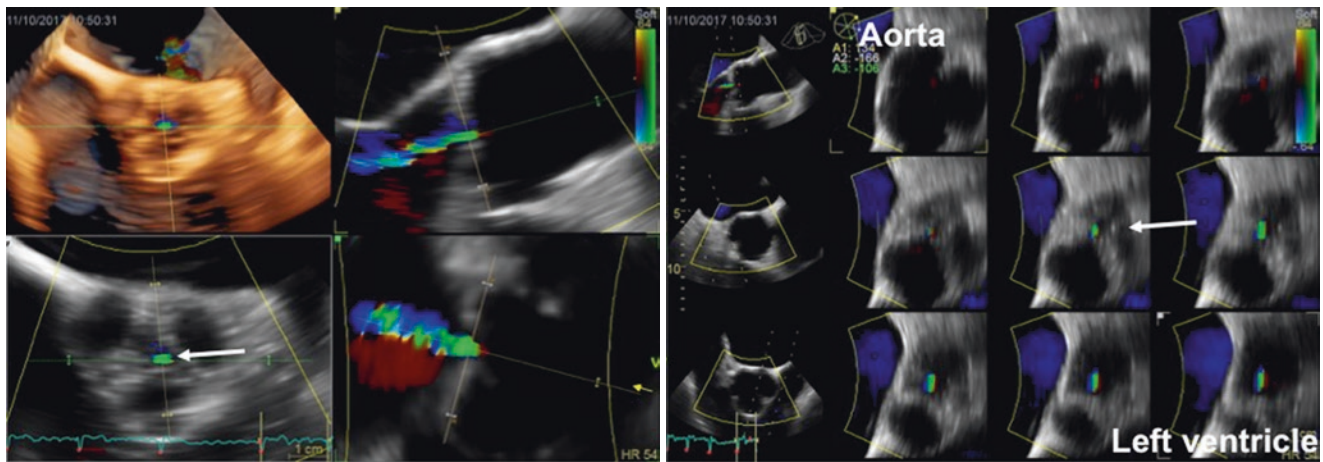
Anatomical study of the aortic complex and measurement of the aortic cusp hinge point to coronary ostia distance using a data set acquired using the transesophageal approach. Left panel (Video 12.2), volume rendering of the aortic complex with the left main coronary ostia (white arrow). Right panel, the data set is sliced at the level of the left main coronary ostial (green line in the right upper quadrant) shown
